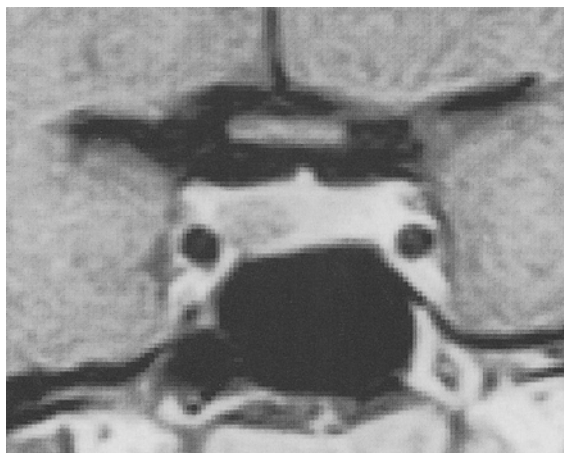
A T1 postcontrast MR (TR 472, TE 26) demonstrating a pituitary microadenoma identified as a focal area of decreased signal within the enhancing pituitary gland. (Image from a 0.2-T Siemens open MR system. Mark Leszczynski, RT, Memorial Open MRI, Houston, Texas, used with permission)
